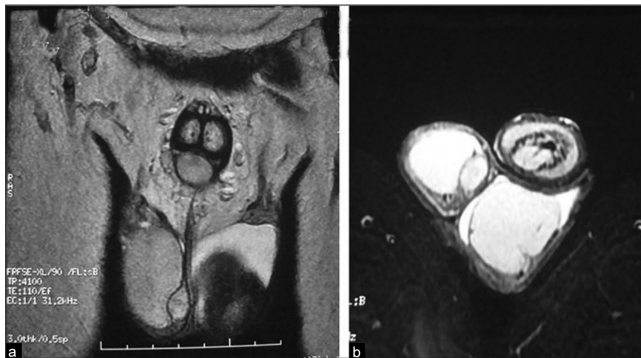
Scrotal MRI shows a well-defined lenticular lesion at lower part of right testis. The lesion displays signals isointense to slightly hypointense on both T1 and T2-weighted images with adjacent hypointense band. The interface with the testis is maintained
